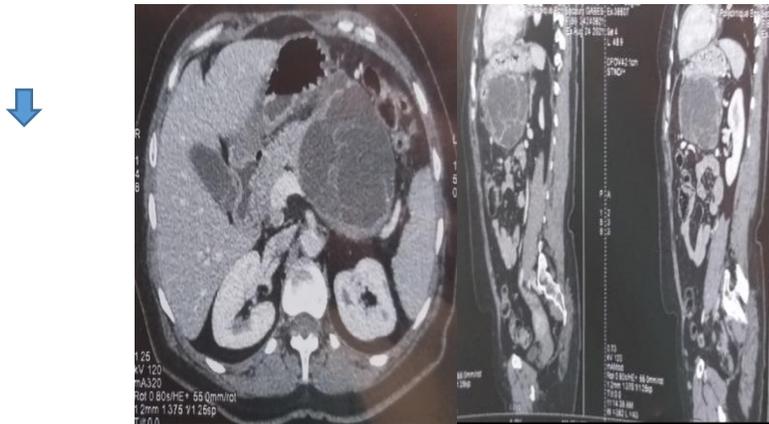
Magnetic resonance imaging shows a multi loculated cystic mass of the corporo-caudal pancreas of 8*9 cm.
